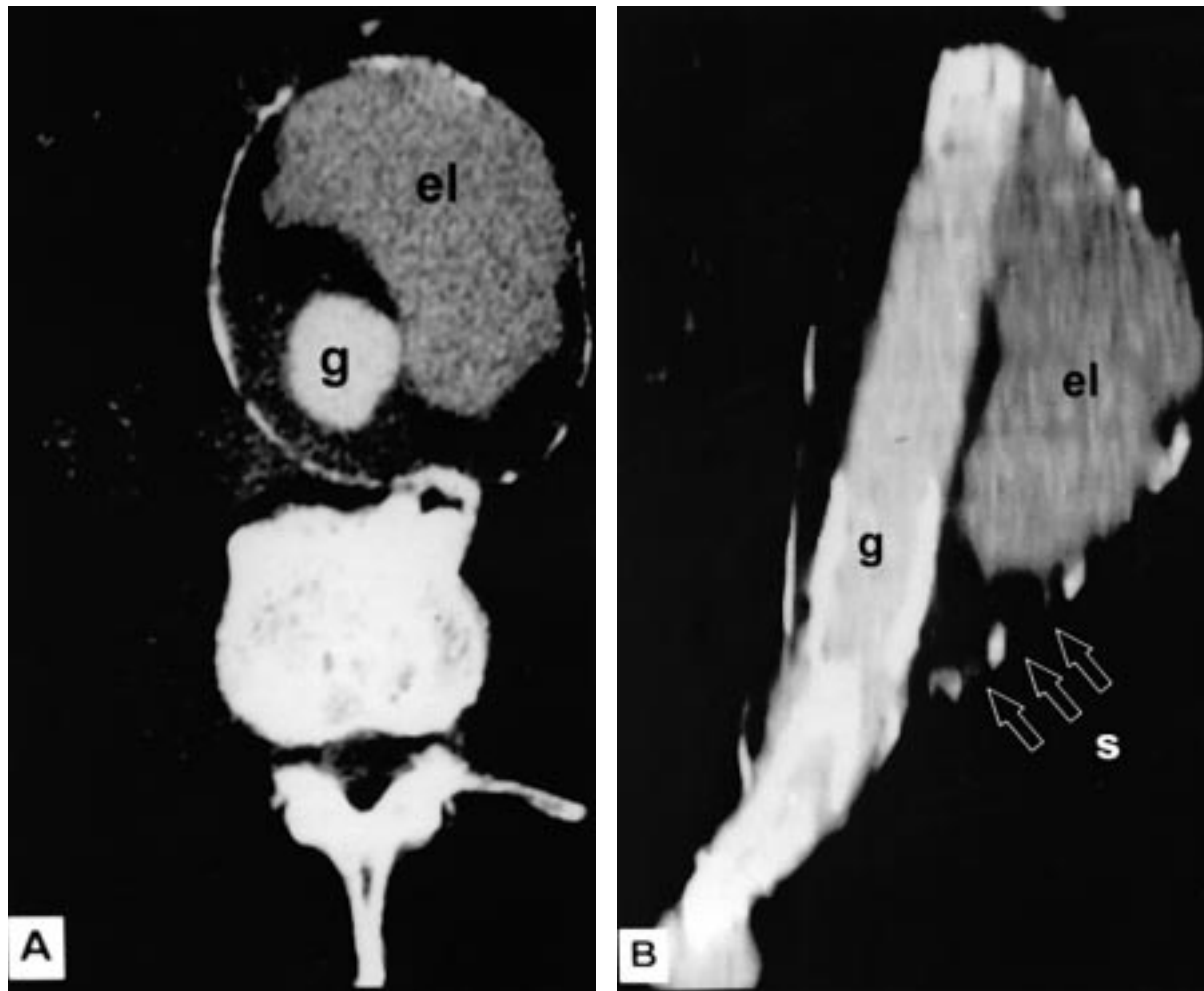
An 88-year-old man underwent elective repair of an 8 cm abdominal aortic aneurysm with an aortoiliac, femorofemoral graft. A, Postoperative CT scan demonstrates large endoleak (*el*) adjacent to endovascular graft (*g*). B, Two-dimensional CT reconstruction shows that endoleak (*el*) originates at proximal portion of endovascular graft (*g*) and ends within distal aneurysm sac (*s*).
